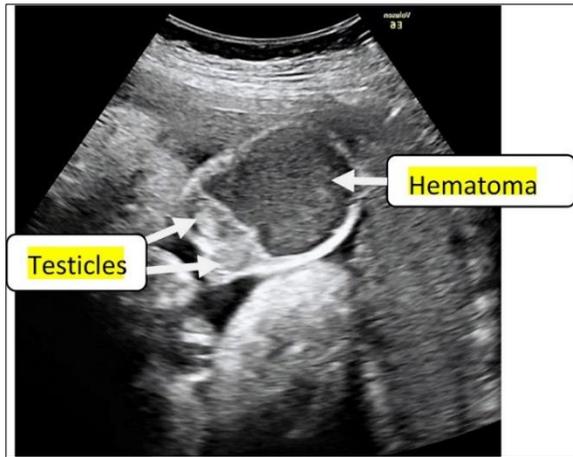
Antenatal Ultrasound Image (36-weeks) showing well-organized haematoma and testicular differentiation.
